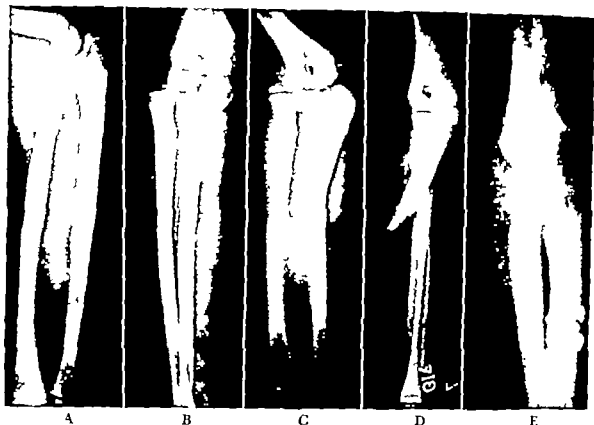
Roentgenograms showing types of Monteggia fracture (A) and (B) Lateral and antero-posterior views of eight year old patient with fracture of ulna high in shaft just below coronoid process and with antero-lateral dislocation of the head of the radius. Closed reduction successful (C) and (D) Lateral and antero-posterior views of nine year old patient's forearm showing fracture of ulna just above its middle. Note displacement of head of radius. Closed reduction was performed but two days later open reduction was carried out. The torn orbicular ligament was found folded in behind the radial head. The ulnar fragments after being reduced openly were fixed with two screws. Supplementary plaster fixation was necessary as the screws alone were inadequate. Today fixation of the ulna would be better carried out by a plate and screws. An intramedullary nail would give excellent fixation in an adult but might damage the epiphysis of the olecranon in a child and lead to growth disturbance (E) Same elbow one and one-half years after operation
